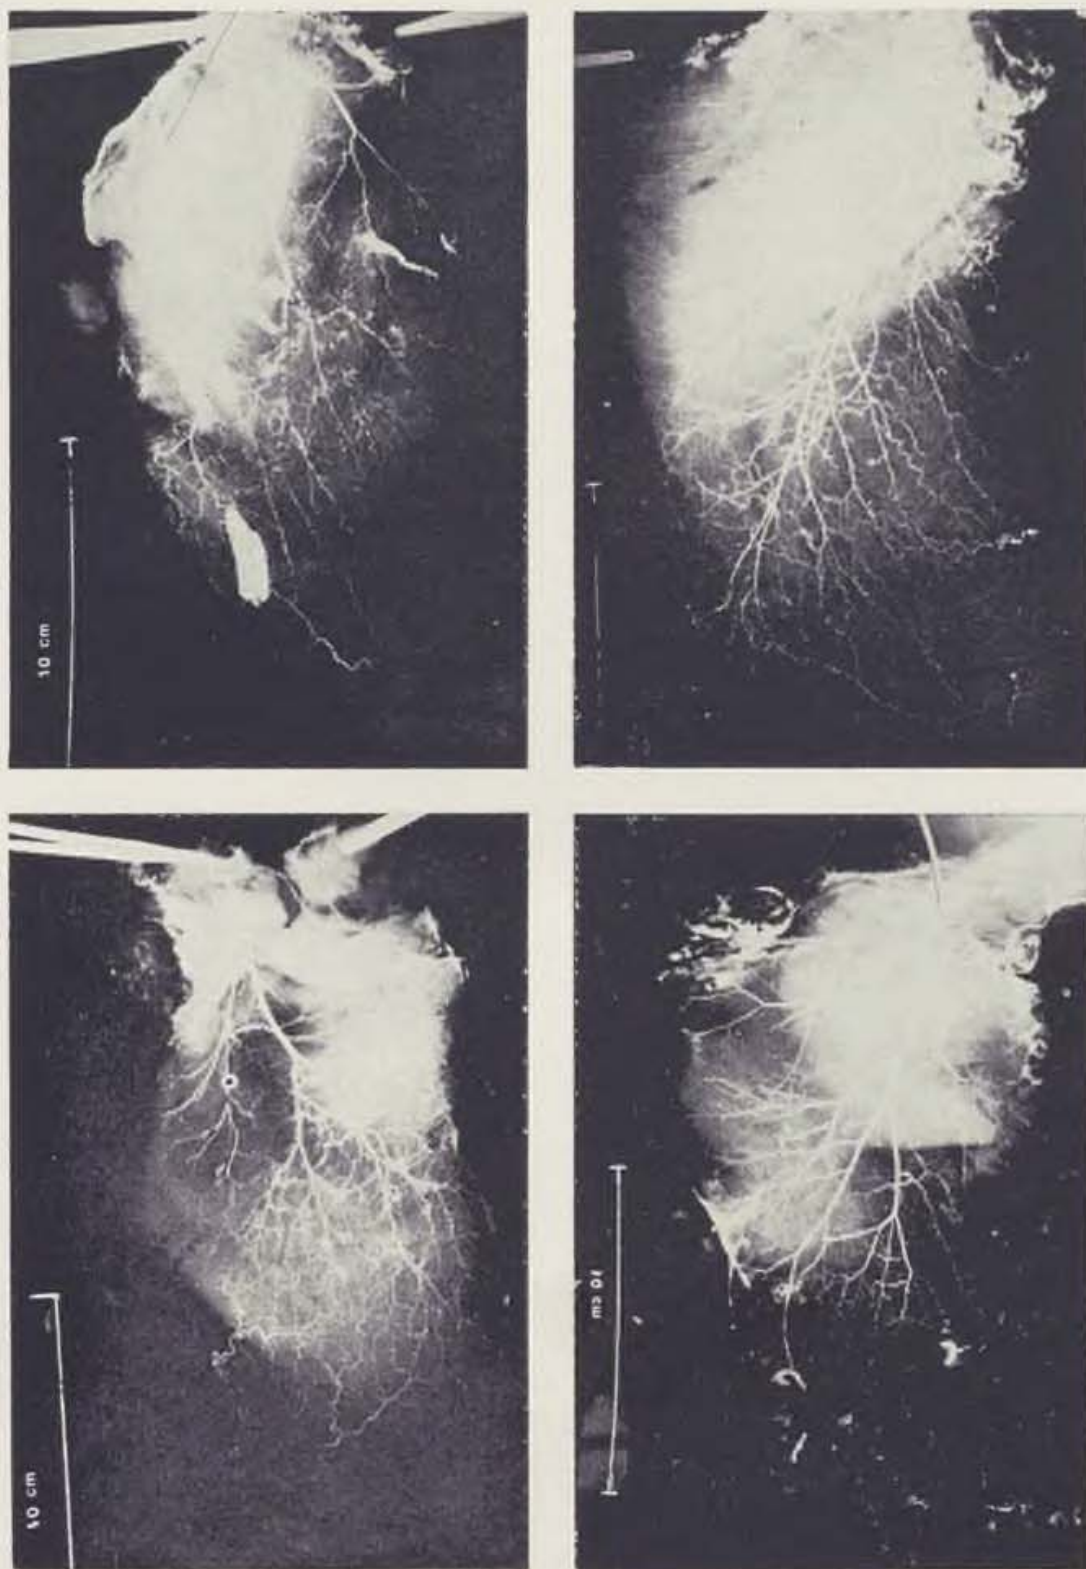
X-ray photographs of pectoralis major muscles. It is possible to recognize the four main branches of the thoracoacromial artery.
